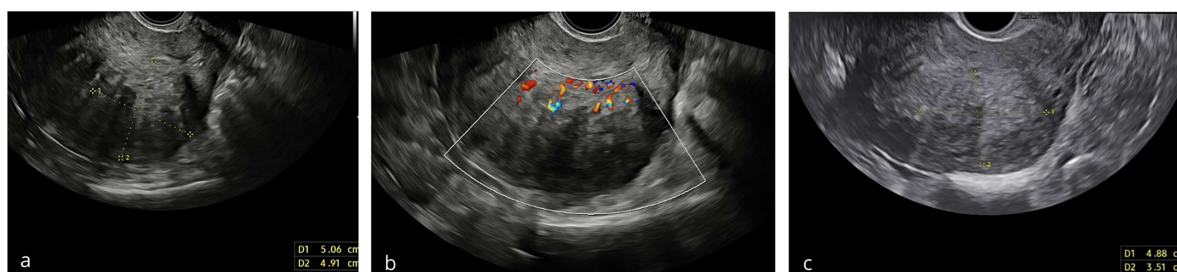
Transvaginal ultrasound images of the uterus in Case 1. (a) Baseline two-dimensional grayscale image showing a focal adenomyotic lesion in the posterior myometrium. The lesion appears heterogeneous with multiple hyperechogenic islands, consistent with focal adenomyosis. (b) Color Doppler imaging at baseline demonstrates moderate translesional vascularity within the adenomyotic area. (c) Follow-up grayscale image at 12 months showing a reduction in lesion size and overall improvement in echotexture, reflecting partial resolution of direct signs of adenomyosis following 12 months of treatment.
